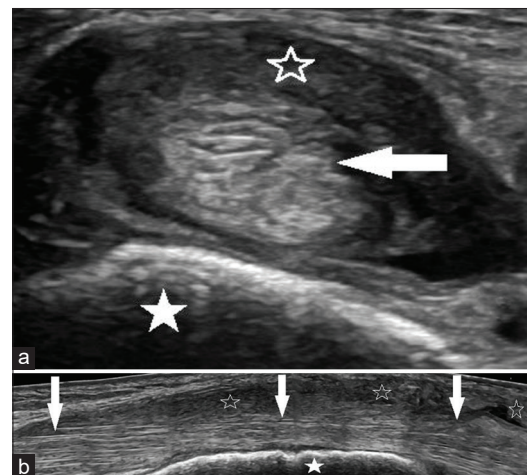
Sonographic images of posterior tibial tenosynovitis in a 62-year-old woman with severe left medial ankle pain. (a) Short-axis image and (b) long-axis panoramic image demonstrate significant posterior tibial tenosynovitis manifest by the complex hypoechoic rind and complex fluid within the tendon sheath (empty stars), circumferentially surrounding the posterior tibial tendon (arrows), adjacent to the medial malleolus (solid stars). The tendon (arrows) is also thickened and heterogeneously hypoechoic consistent with associated tendinosis
